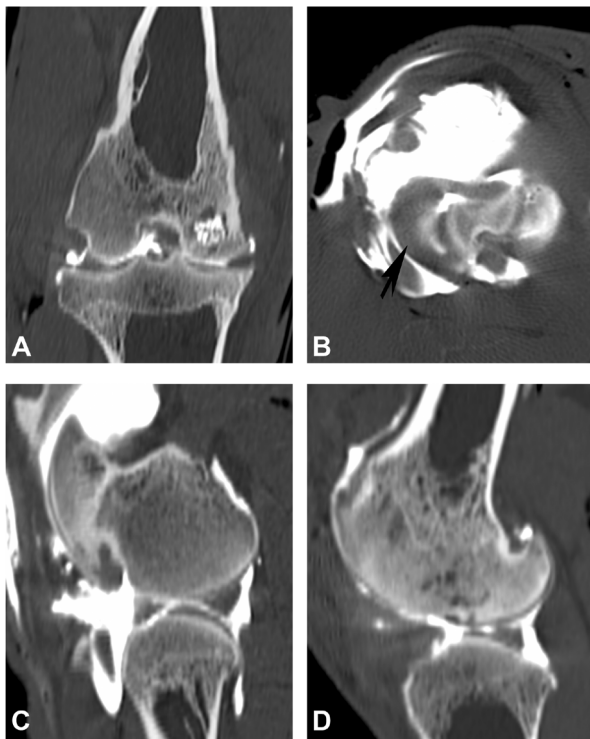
Radiological evaluation of the menisci. Arthro-CT scans of a representative sample: dorsal (A), transverse (B) and sagittal (lateral side: C; medial side: D) are shown. Note the presence of the biphasic scaffold in (A). The arrow in (B) points at the lateral meniscus.
